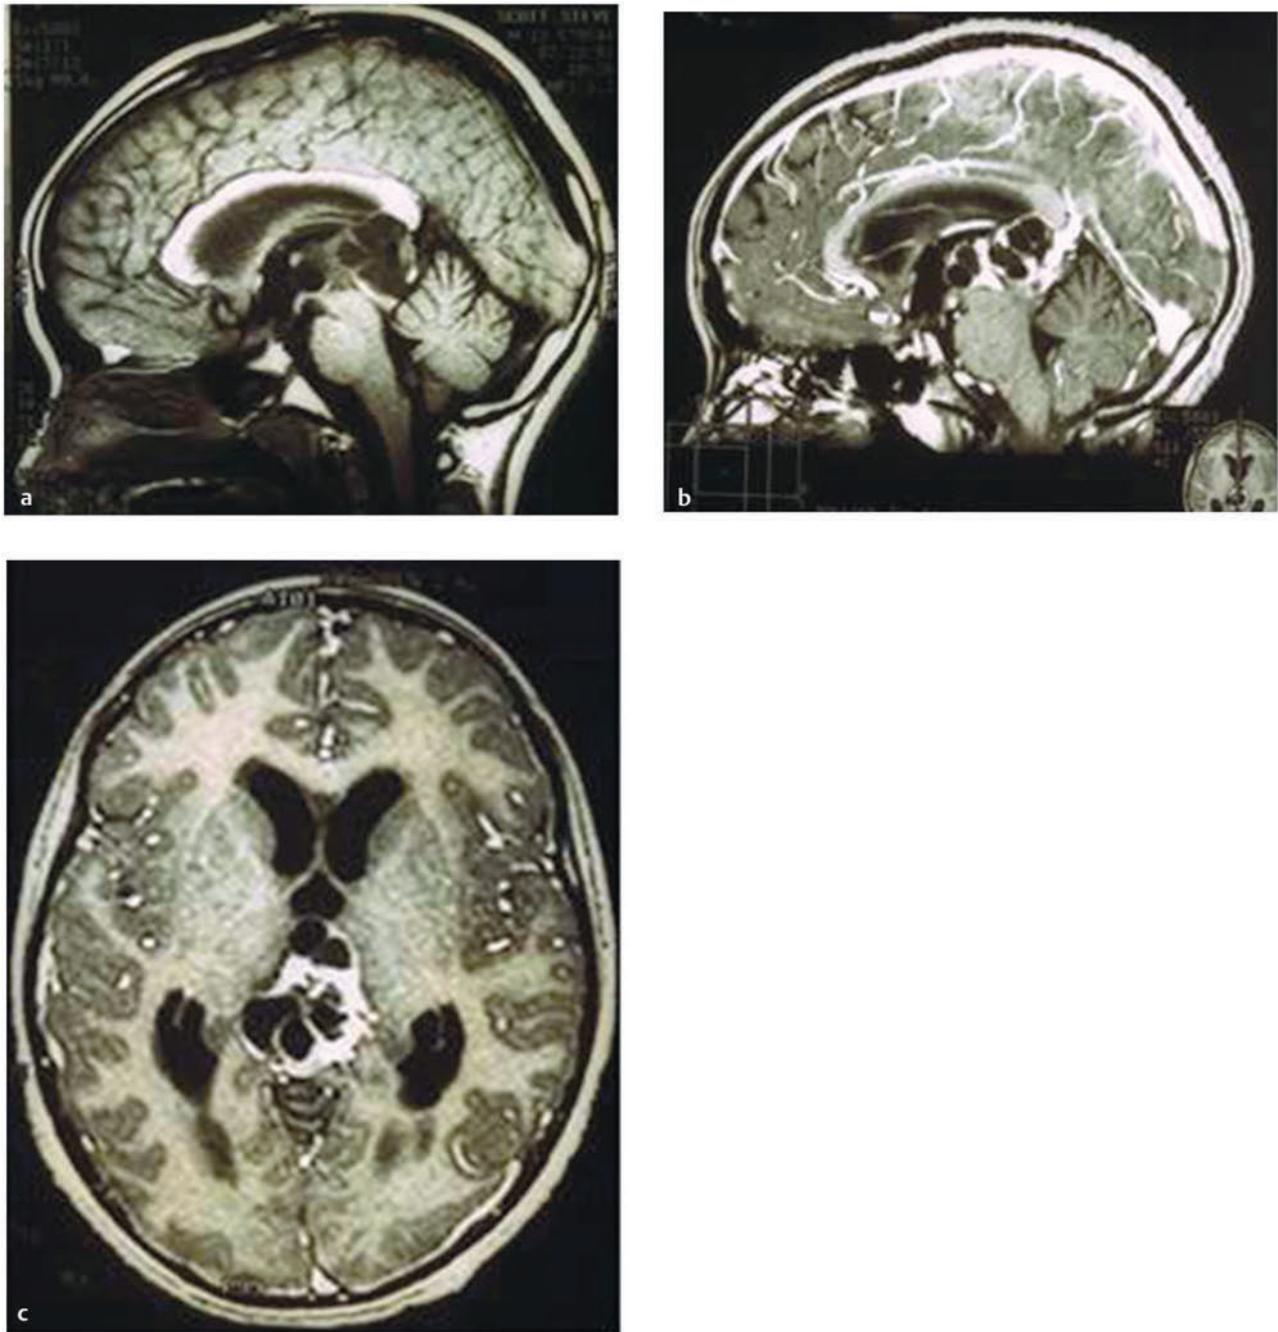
(a) Mature teratoma is shown on precontrast sagittal magnetic resonance (MR) image. (b) Note inhomogeneous enhancement on postcontrast sagittal and (c) axial MR images.
